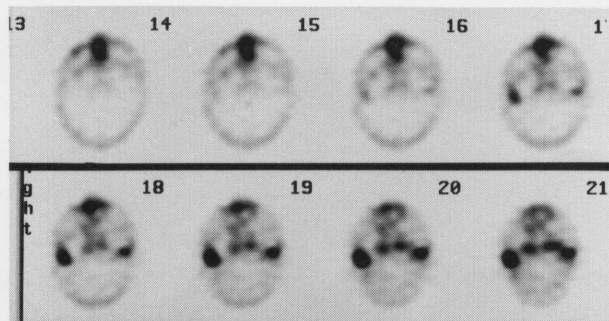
Thallium-201 single photon emission computed tomography, early oblique transaxial images showing slightly high to normal uptake in the nasal area.
